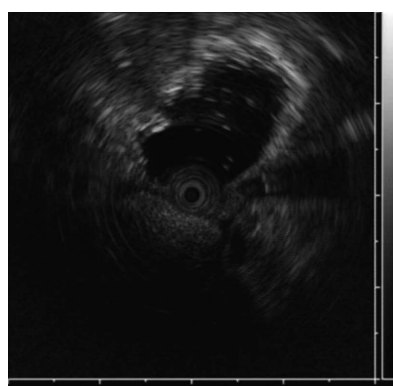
Endoscopic ultrasonography showed a well-circumscribed submucosal tumor with a hyper-echoic appearance.
